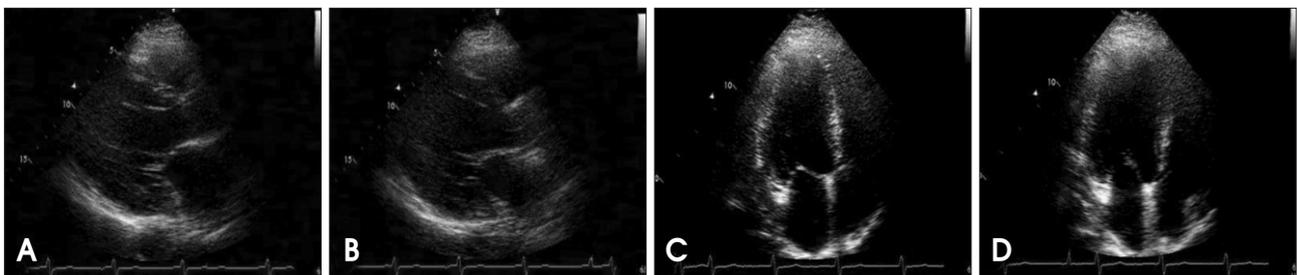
Two-dimensional echocardiography on admission. Parasternal long axis view (A: end-systolic, B: end-diastolic) and apical 4 chamber view (C: end-systolic, D: end-diastolic) show eccentric left ventricular hypertrophy and enlarged left atrium.
